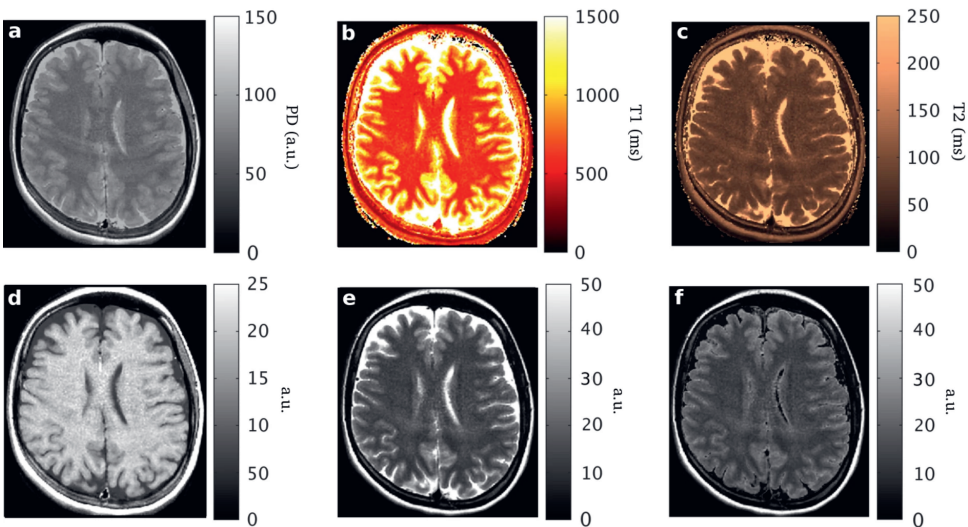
The parametric maps and synthetic images as obtained with MAGIC : (a) PD (proton density, a.u.); (b) T1(ms); (c) T2 (ms); (d) synthetic T1-weighted; (e) synthetic T2-weighted; (f) synthetic T2-FLAIR.
